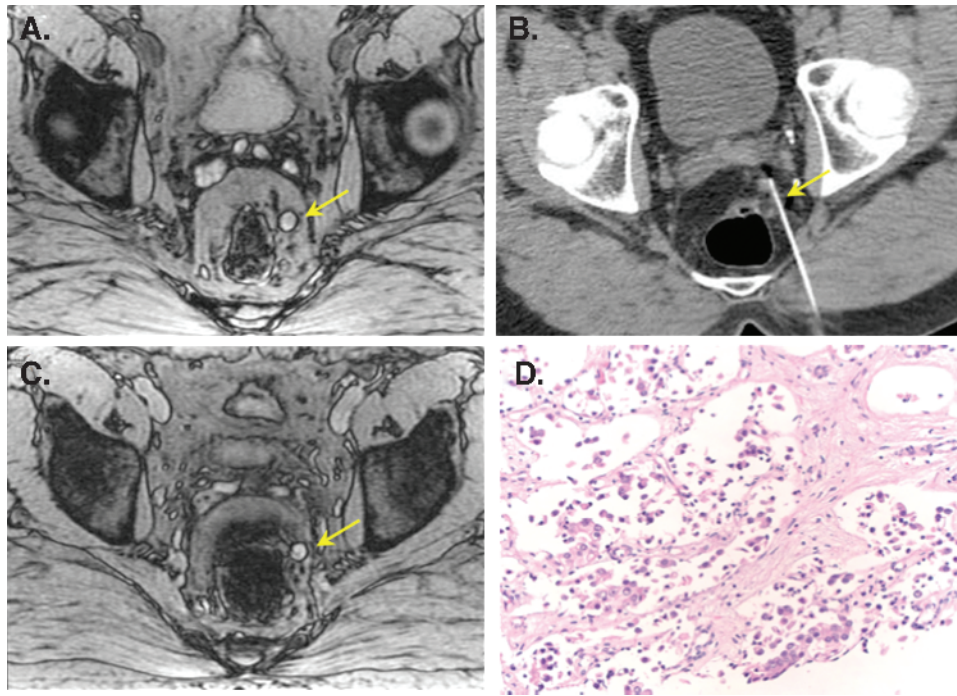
Malignant left perirectal node. (A) Axial precontrast gradient-echo image shows a hyperintense left perirectal lymph node (arrow). (B) 24 hours after ferumoxytol, the node shows no signal change indicating malignant infiltration. (C) CT-guided biopsy of the node. (D) Subsequent pathologic evaluation showed architectural distortion from malignant infiltration of prostate cancer.
